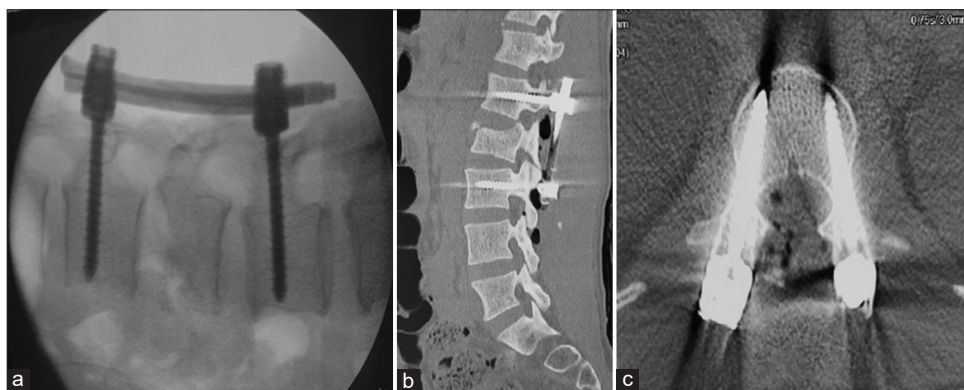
Intraoperative lateral fluoroscopic view of screw placement (a), postoperative sagittal (b), and axial (c) views of CT scan showing placement of transpedicular screws.
